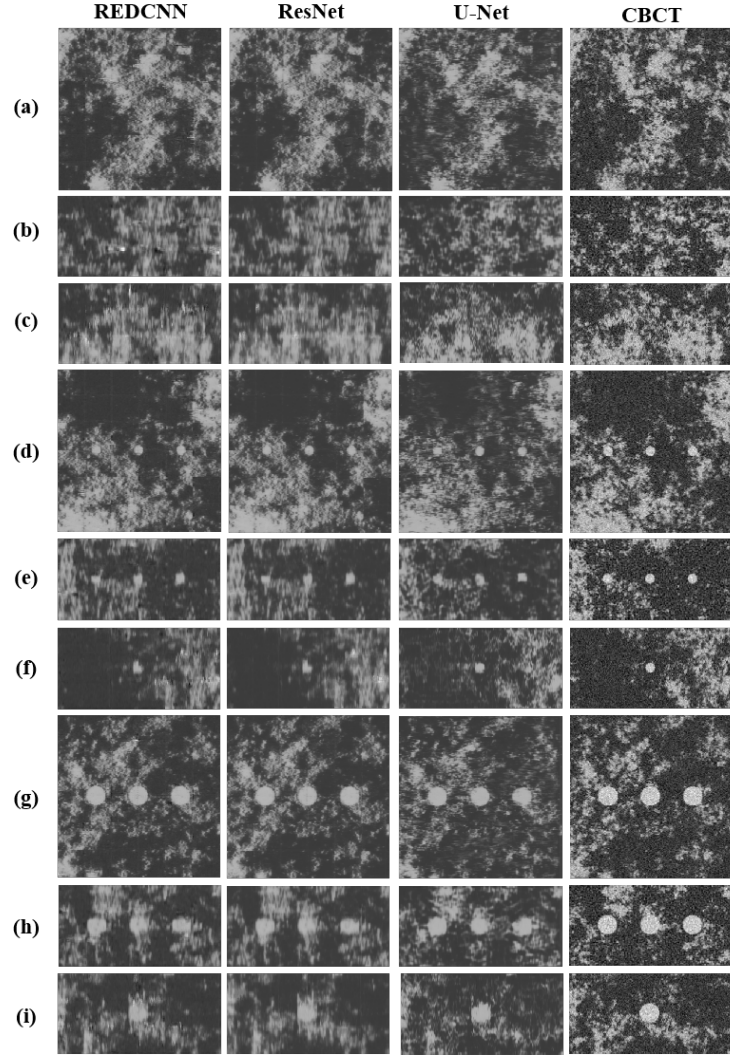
Results for various Phase-2 CNN. Deblurred images by the proposed method with REDCNN, ResNet, U-Net in Phase 2, and CBCT images (from left to right). Images without mass lesion for (a) axial, (b) coronal, and (c) sagittal planes; images containing 4 *mm* lesions for (d) axial, (e) coronal, and (f) sagittal planes, and images containing 2 *mm* lesions for (g) axial, (h) coronal, and (i) sagittal planes. The display window is $[0.03 \ 0.10]$ in cm^{-1} .
